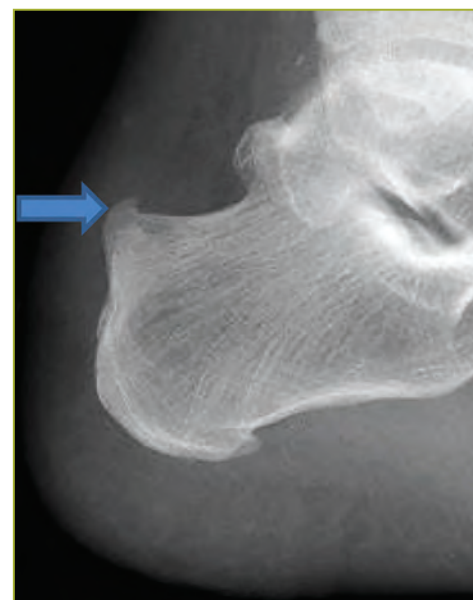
Radiograph showing superior calcaneal tuberosity prominence (arrow), seen in two of the eight patients with sleeve avulsion injuries.
